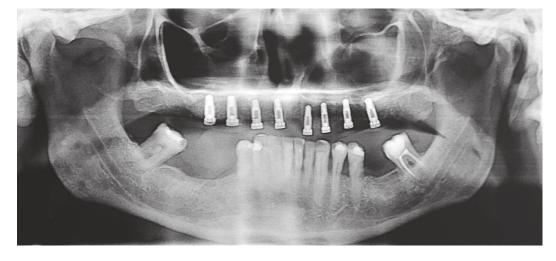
Panoramic radiograph after implant placement surgery (Case 1).
